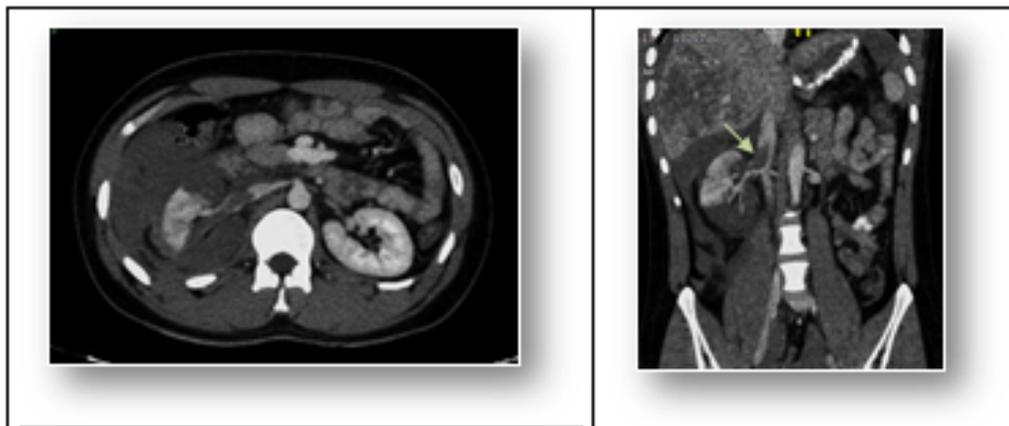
Axial and Coronal nephrographic phase CT images in a patient of blunt abdominal trauma, showing peri-renal hematoma with non-enhancement of the lower pole of right kidney s/o infarction due to thrombosis of the right renal vein extending into the IVC (arrow) s/o Grade 4 renal injury. The right renal artery however was intact. Also seen were multiple liver contusions-lacerations with mild peri-hepatic fluid.
